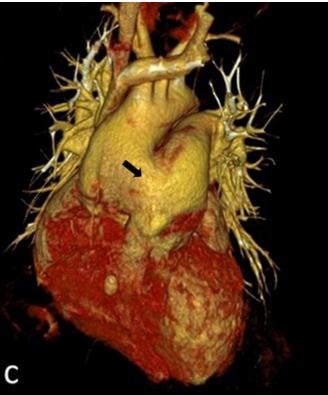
Axial sections of CT angiography at the level of ascending aorta (A,B) shows a large defect (arrowheads) between the ascending aorta and the proximal main pulmonary artery. There is dilated main pulmonary artery, its right (RPA) and left branch (LPA). Volume rendered image (C) shows communication between the ascending aorta and proximal main pulmonary artery (arrow) about 16 mm from aortic root. Left subclavian, left common carotid and innominate artery are arising from the arch of aorta.
